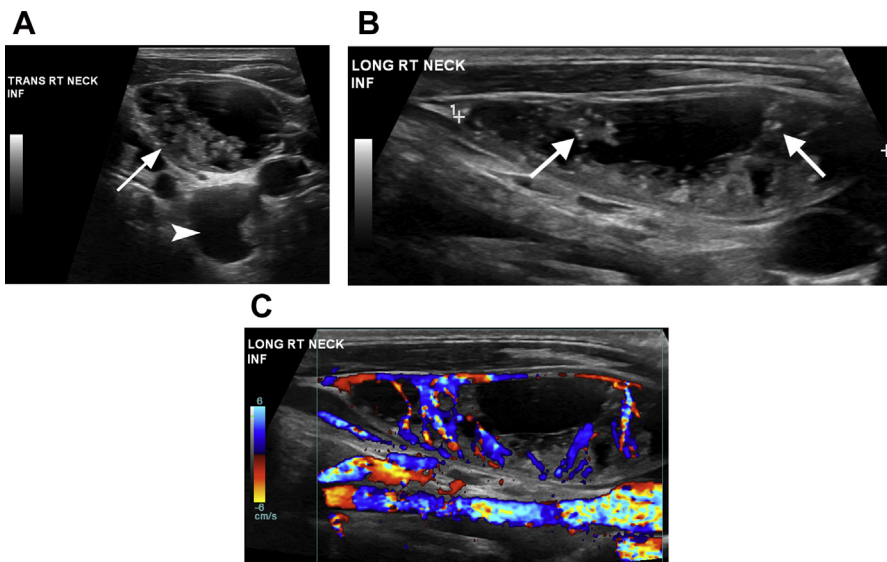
A 20-year-old man presented with a right neck mass initially thought to be a branchial cleft cyst. Surgical excision revealed metastatic papillary thyroid cancer. (A) Transverse gray-scale ultrasound demonstrates 2 abnormal lymph nodes. The larger lymph node shows solid and cystic changes (arrow), and the smaller lymph node is entirely cystic (arrowhead). (B) Longitudinal gray-scale image demonstrates multiple PEF (arrows) in the solid component. (C) Color Doppler ultrasound shows hypervascularity within the solid portions of the metastatic lymph node.
